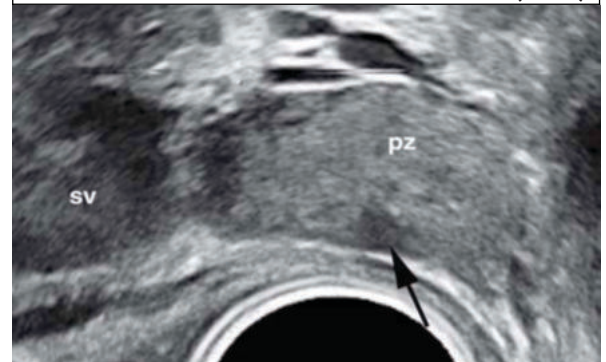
On Transrectal Ultrasonography, Sagittal Image showed a Slightly Echogenic Peripheral Zone (pz) and a Hypoechoic Nodule (Arrow) in the Peripheral Zone and the Seminal Vesicle (sv)
